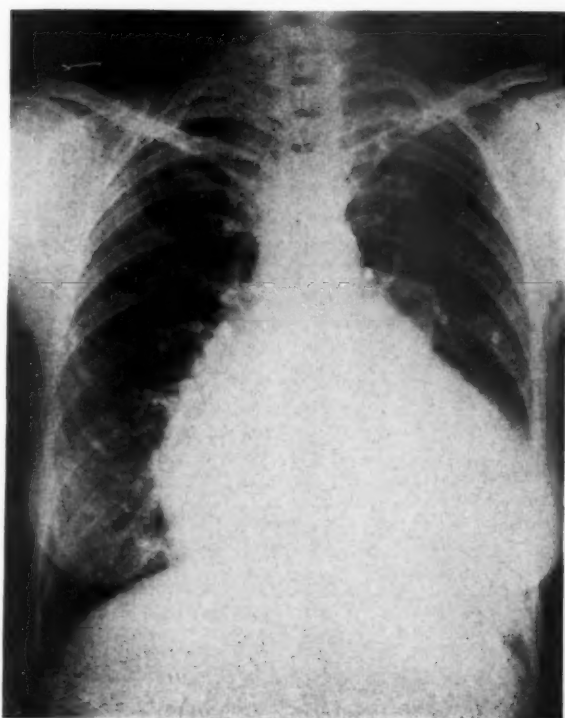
April 14, 1948, roentgenogram of chest before treatment.
